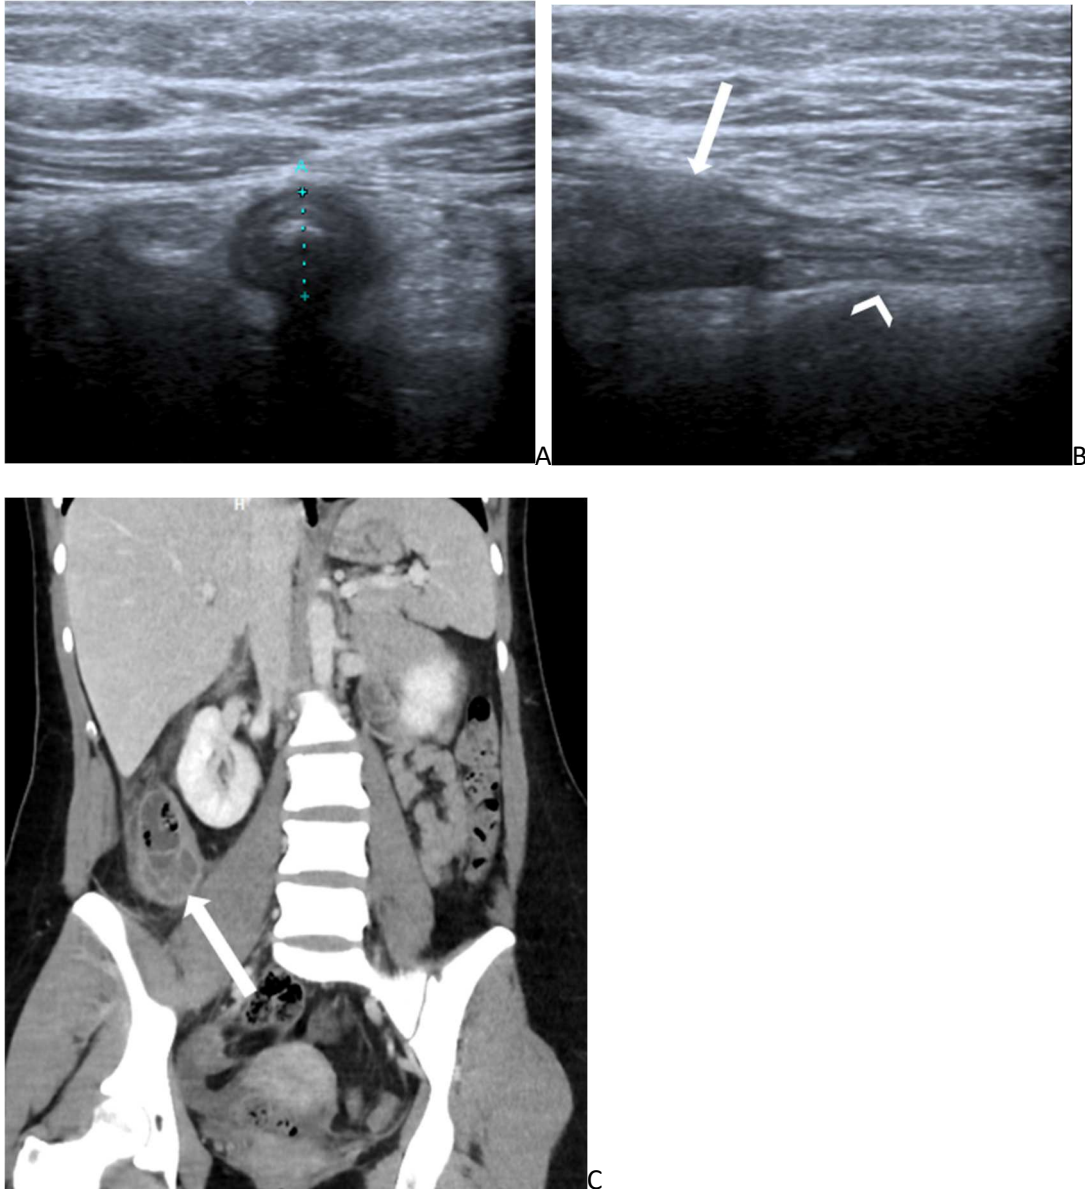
Acute appendicitis at ultrasound in axial (a) and longitudinal plane (b), with a diameter of 12 mm (clippers) and fat stranding (arrow).
